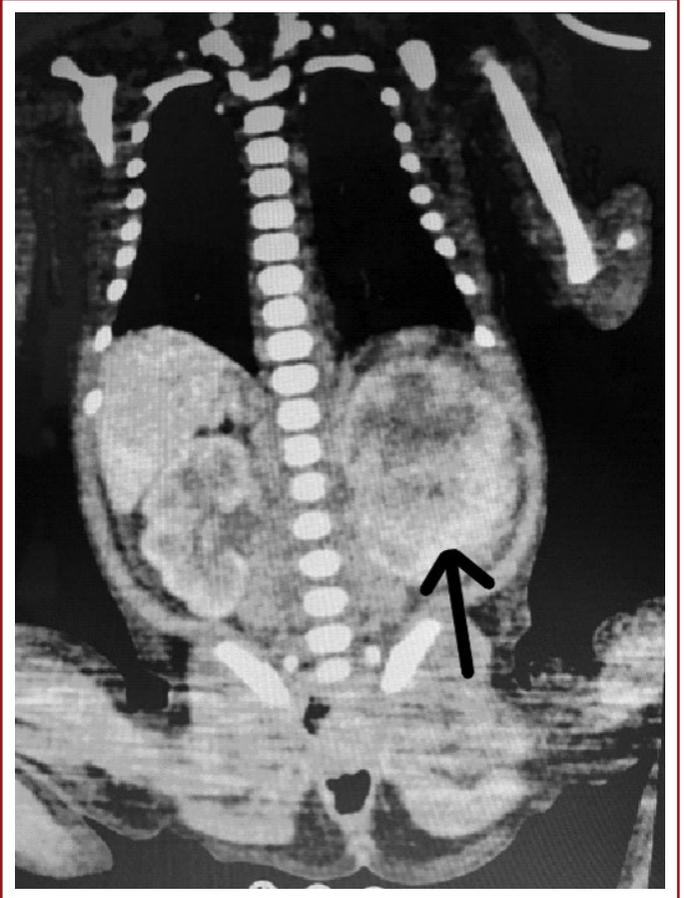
Abdominal CT, 77x65 mm, solid mass appearance with low densities, which may belong to cystic degenerate areas or focal caliectasis.
